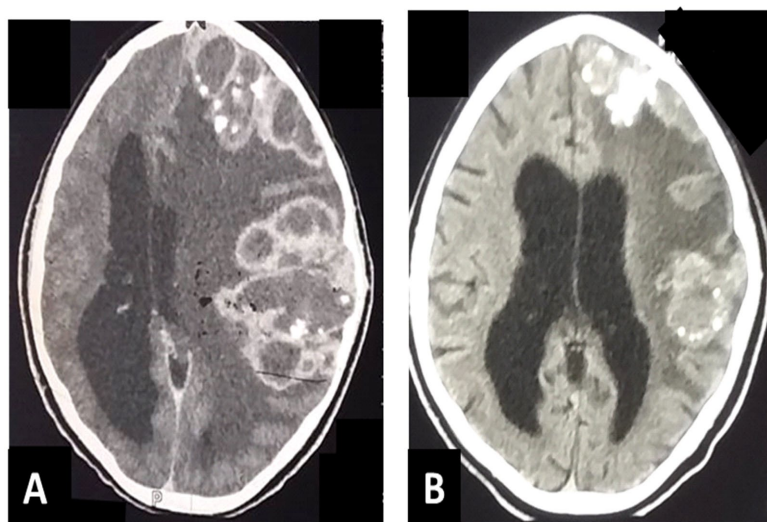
(A) Cerebral CT scan showing multiple left fronto-temporal parenchymal lesions with significant mass effect suggesting a tumor process. (B) Follow-up cerebral CT scan at 3 months showing left fronto-parietal calcifications and the disappearance of the midline.
